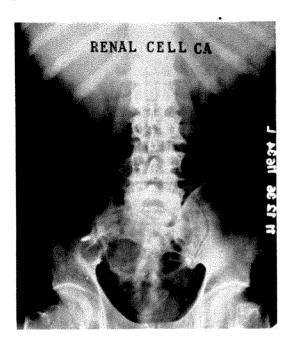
Roentgenogram showing confident osteolytic involvement of posterior right i ium and adjacent portion of sacrum from renal cell carcinoma. No other bone metastasis.
